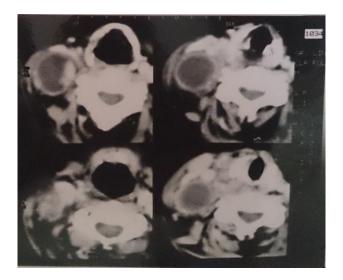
CT of thyroid showing central mass with necrotic lymph nodes necrosis in thyroid cancer.
